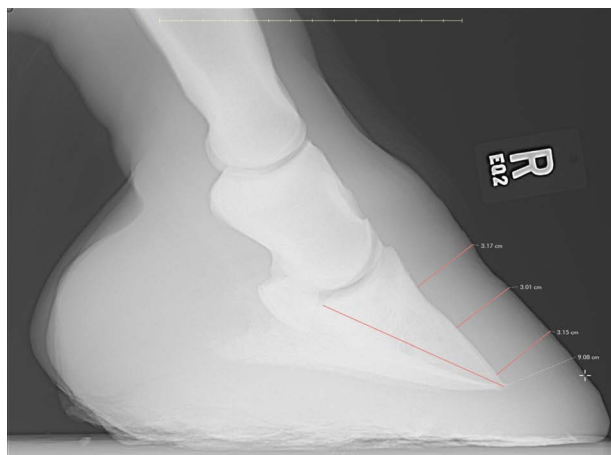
Lateromedial right front foot radiograph with measurements of the dorsal hoof wall and length of the distal phalanx.
